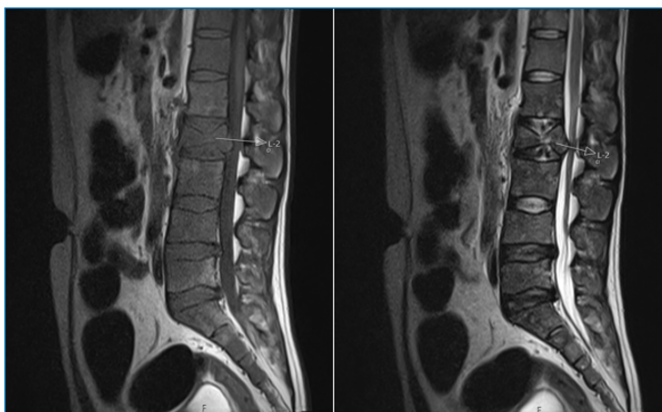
Lumbar MRI showing lumbar fracture
